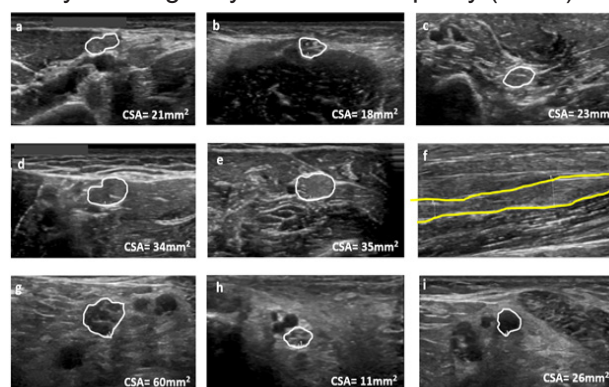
Ultrasonographic image of the right peripheral nerves at median forearm (a), elbow (b), mid-arm (c); ulnar forearm (d), mid-arm (e); tibial knee (g), ankle (h); and fibular knee (i) of one of the CIDP patients. Total UPSS - A score: $(2 + 2 + 2 + 2 + 2 + 0 + 2) = 14$. (f): uneven hypertrophy of the right median nerve in the mid-arm.
